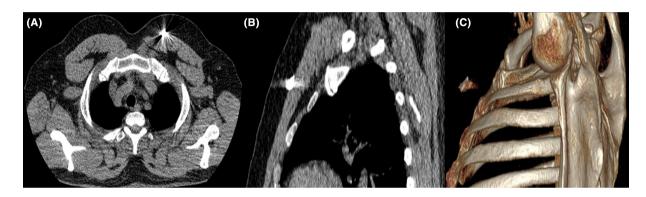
Axial (A), Sagittal (B) and 3-dimensional virtual rendered images of chest CT (C) showing dense structure abutting pectoralis major and causing beam hardening artifacts.
